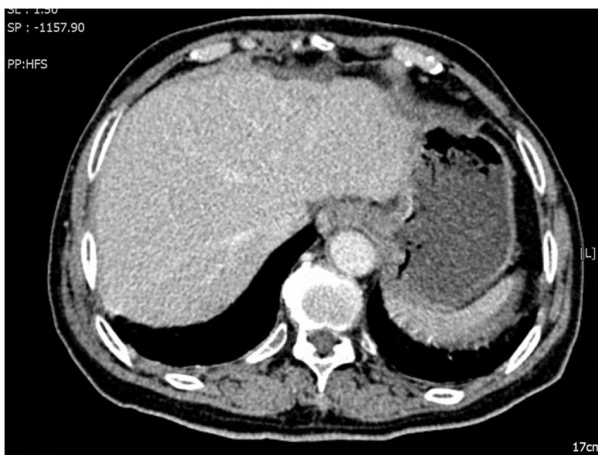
Enhanced computed tomography scan after chemotherapy on day 2. No evidence of the lesion at the apex of the right lobe of the liver can be observed.
